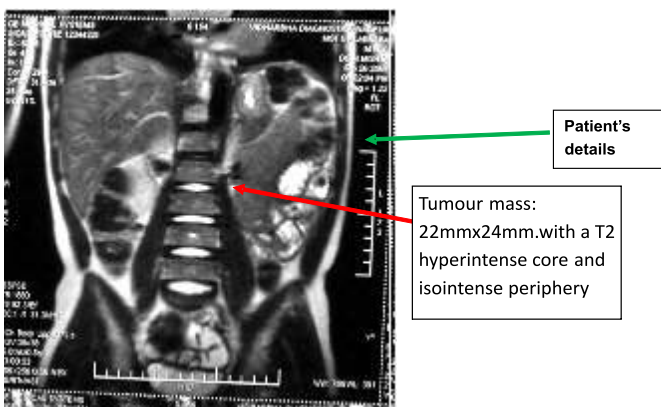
Tumour mass and Patient's details in the MRI scan done on Feb 26th, 2009
